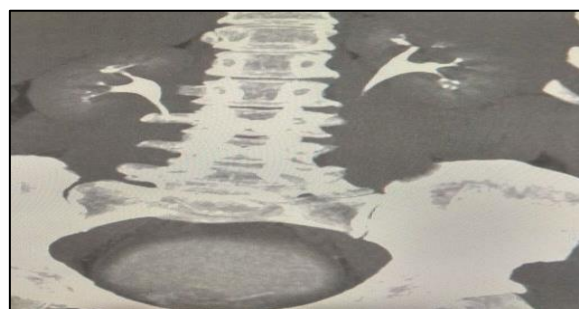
Coronal MIP Post Contrast CT Image showing synchronous Nephrographic phase and excretory phase by Split-Bolus protocol.
